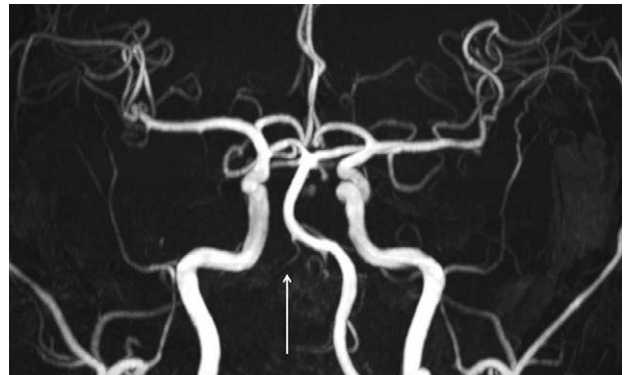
Follow-up MR angiography shows good posterior circulation and compensation from the contralateral vertebral artery with no change from the previous CT angiography.
